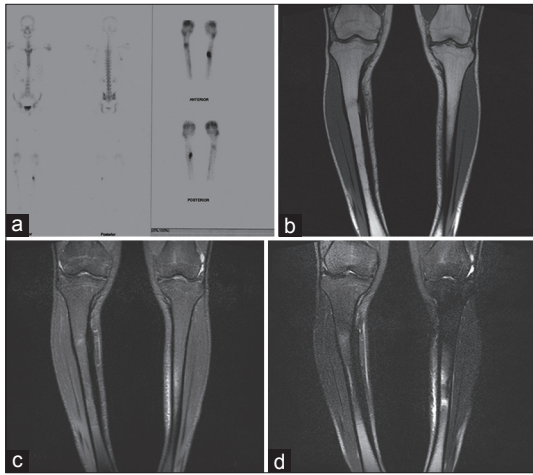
(a) Bone scan revealed sharply margined area of increased signal intensity in upper thirds shaft of right femur and also in middle thirds shaft of left femur, (b) T2-weighted coronal magnetic resonance imaging (MRI) figures revealed a hypo intense band with cortical break in right femur, (c) T2-weighted coronal MRI revealed hyper intense signal intensities in upper thirds shaft of femur on right side and middle thirds shaft of femur on left side, and (d) short-tau inversion-recovery coronal MRI figures revealed hyper intense signal intensities in the corresponding anatomical locations shaft of tibiae. Diagnosed as Grade IV stress on right side and Grade II on left side
